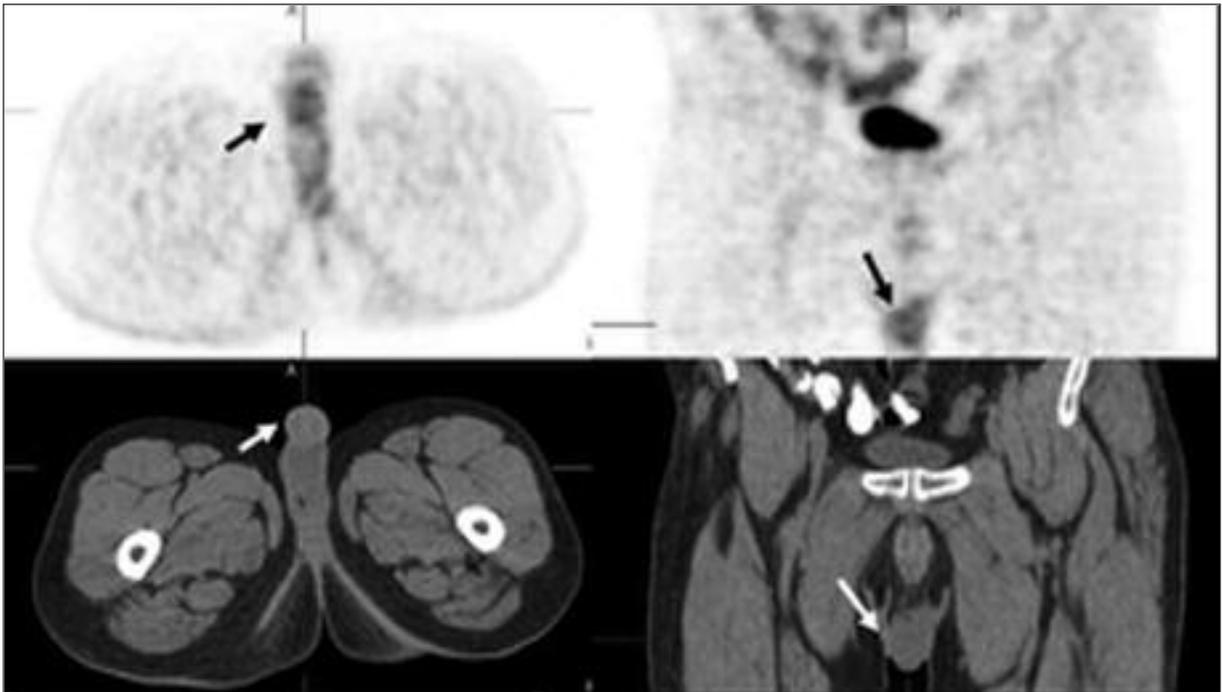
Right testis (retractile testis) is not seen in the scrotum in the second PET/CT examination.
